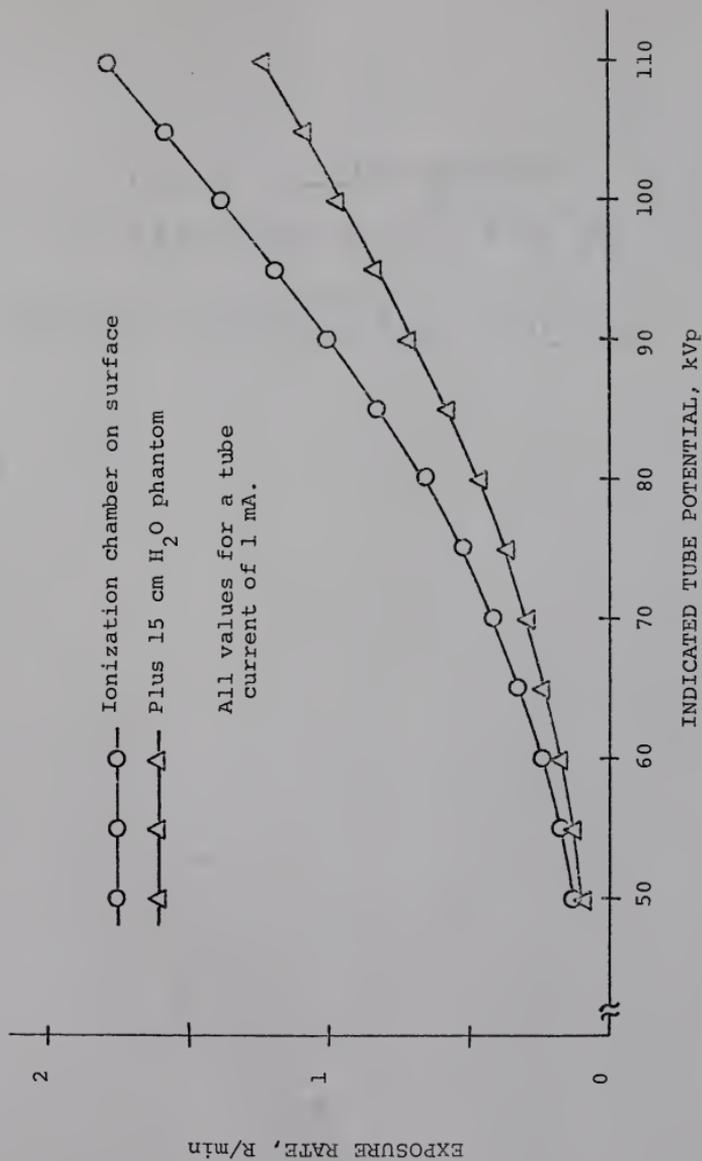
Measured Exposure Rate at Cradle Surface from Under Table Fluoro/Cine X-ray Tube.
